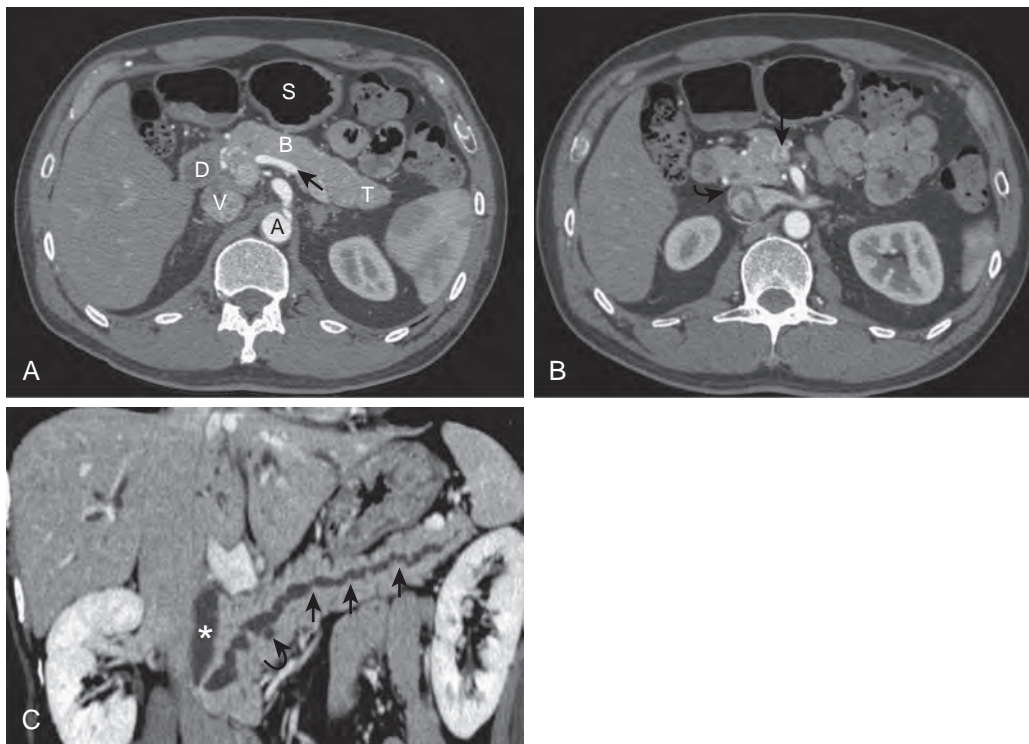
Normal pancreas on CT. Because of the oblique line of the pancreas, the entire organ is seldom seen on a single image. A. Image through the body (B) and tail (T) of the pancreas. The splenic vein (arrow), which lies immediately dorsal to the body of the pancreas, is an excellent landmark. A, Aorta; D, duodenum; S, stomach; V, inferior vena cava. B. Image from the same patient obtained 1 cm caudal to A demonstrates the uncinus process of the pancreas. The superior mesenteric vein (arrow) is difficult to visualize on this image that was obtained early in the administration of the contrast material bolus. However, the arterial anatomy is well demonstrated. Curved arrow, Dorsal pancreatic artery. C. Coronal curved multiplanar reconstruction image of the pancreas demonstrates a small, side branch, intraductal papillary mucinous neoplasm (curved arrow). This technique is useful in imaging of the pancreatic duct in one image (straight arrows); asterisk, common bile duct.
